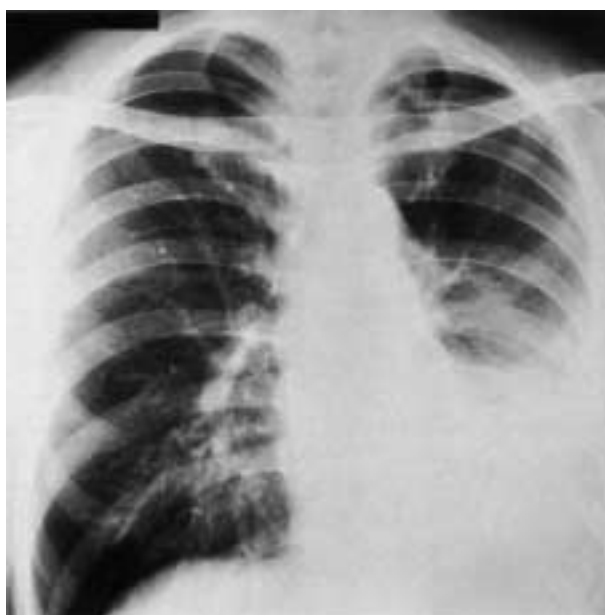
Posteroanterior chest roentgenogram at the time of discharge. Pleural effusion had been absorbed, but considerable adhesion and thickening of the pleura remained. The mediastinum was shifted to the left.
